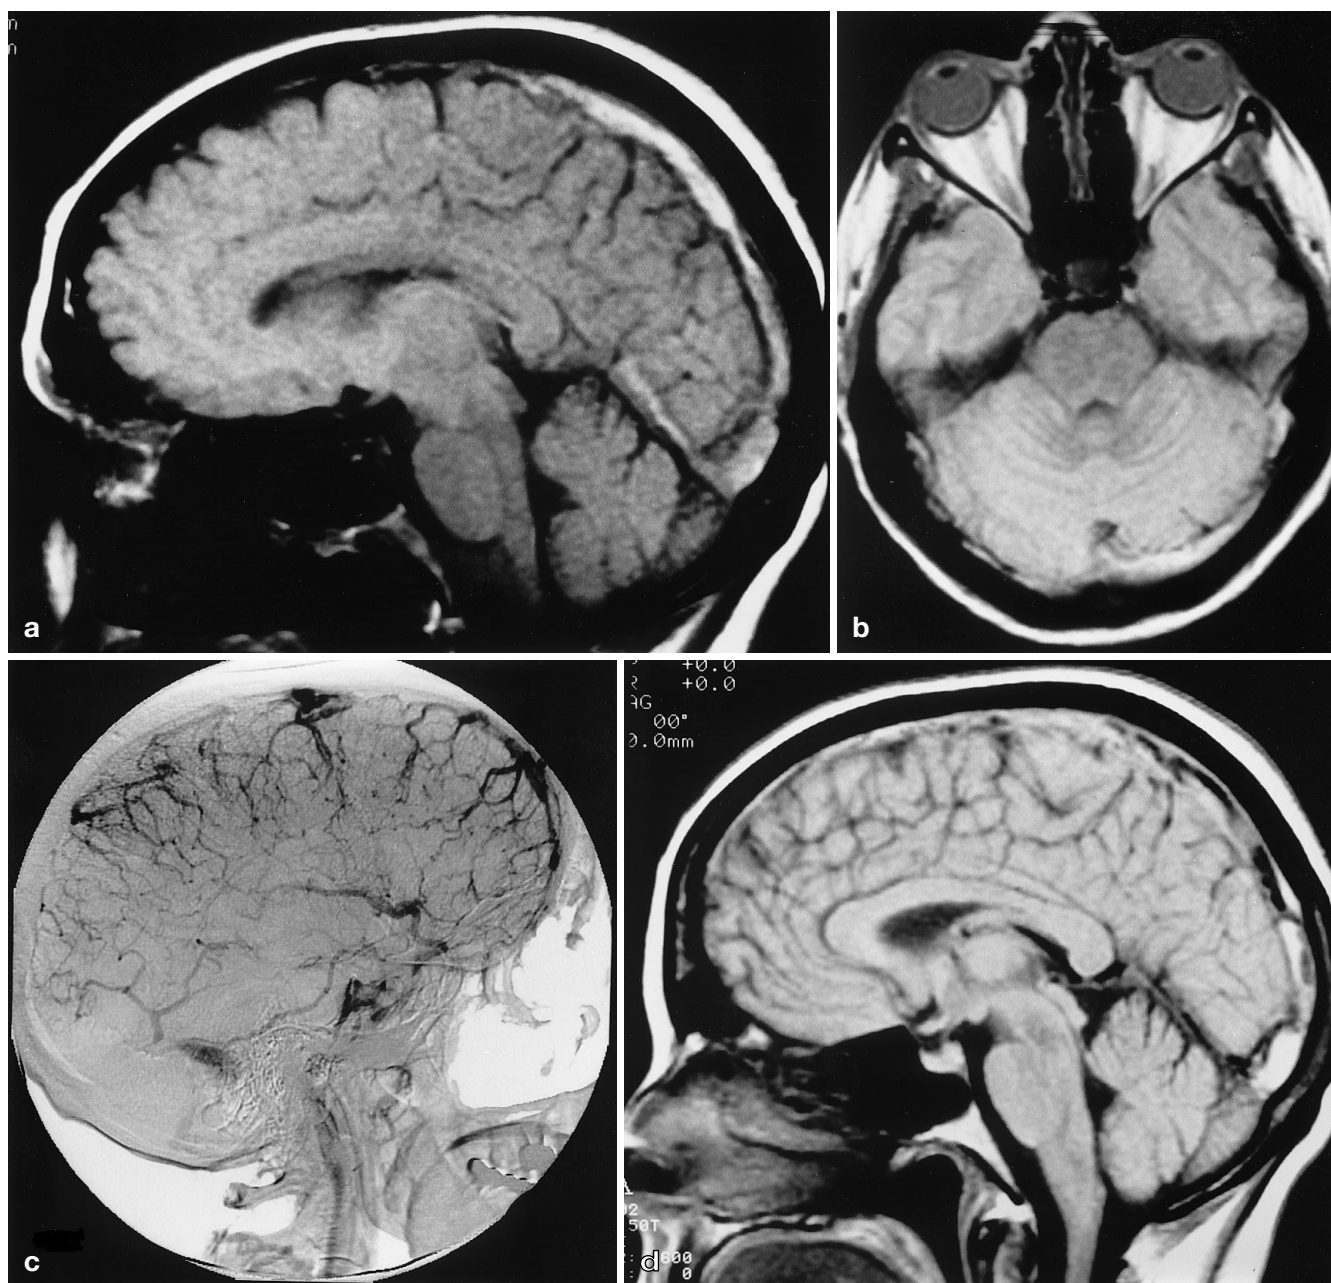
Case 1. a Sagittal T1-weighted image shows signal iso-intense with brain parenchyma in the internal cerebral vein, vein of Galen and high signal in the straight sinus and superior sagittal sinus (SSS). b Axial proton-density image shows high signal in the left lateral sinus. c Left carotid angiogram, lateral projection: internal cerebral vein, vein of Galen, straight sinus, torcular herophili and SSS are not seen. d Sagittal T1-weighted image 15 days later shows complete recanalisation (signal void) of the left internal cerebral vein (*arrow*), and partial recanalisation of the straight sinus and SSS
